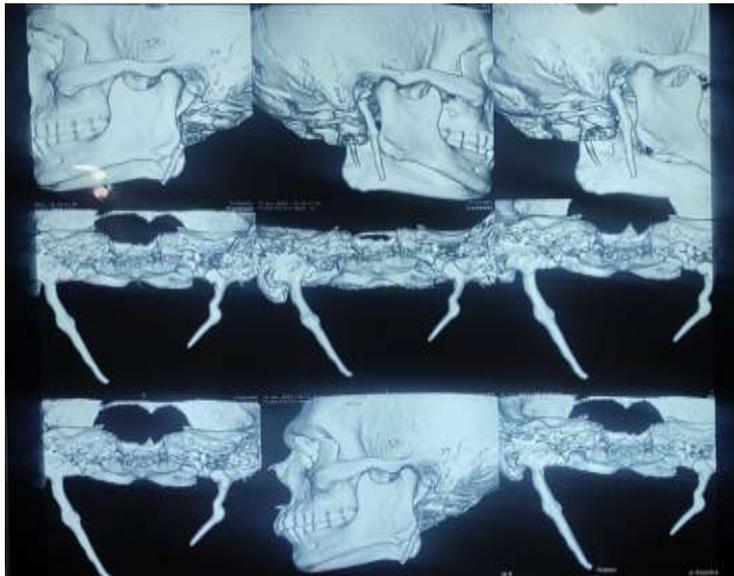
CT Styloid process with TM joint
